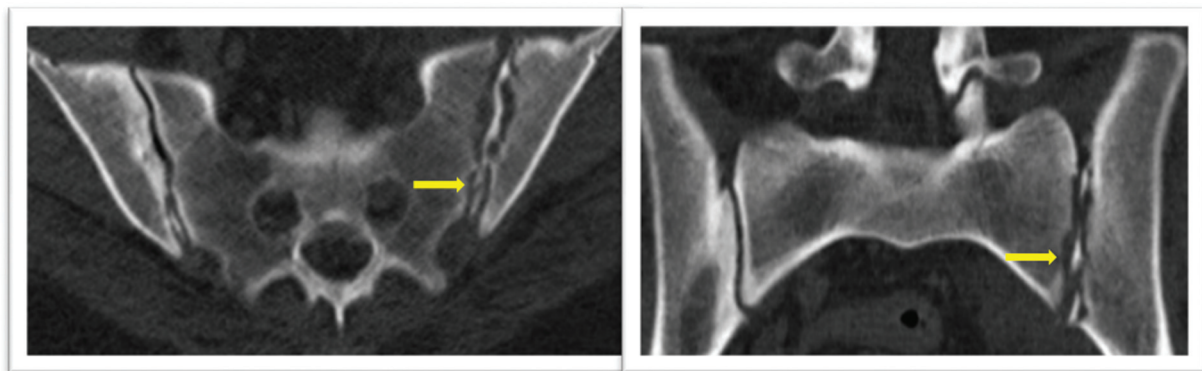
Axial (left) and coronal (right) sections of a pelvic computed tomography scan showing lysis of the subchondral bone, which determines the irregularity of its contour, with linear fragments of subchondral bone in the joint space (yellow arrows) associated with widening of the joint space.
